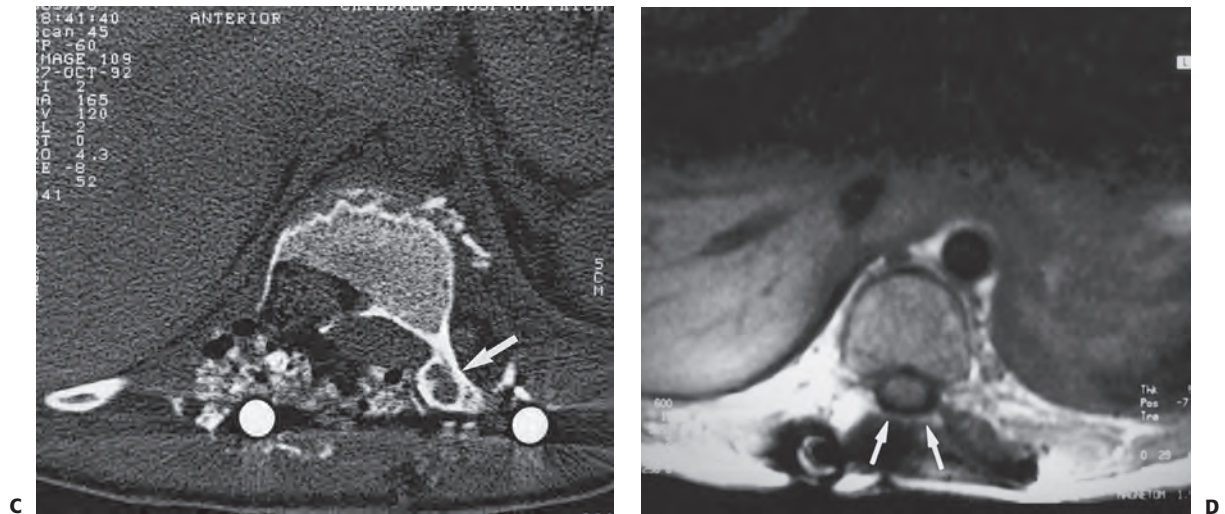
(continued) C: Postoperative CT scan of the same patient showing an adequate view of the surgical area. D: Postoperative MRI of a patient with a previous spinal tumor again adequately showing the surgical site to monitor for recurrence or persistent tumor.
